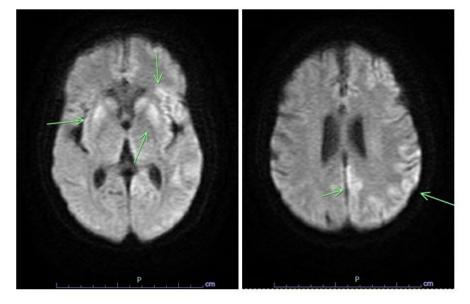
Brain MRI (diffusion-weighted imaging) showing restricted diffusion predominantly in the lateral and paramedian aspects of the left parietal lobe, the paramedian left frontal lobe, left insular cortex and basal ganglia bilaterally
